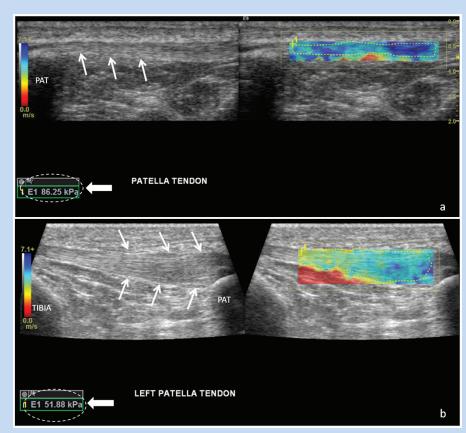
Shear wave elastography (SWE) of the patellar tendon. (a) The grayscale ultrasound image shows a normal patellar tendon (arrows). The corresponding SWE color map demonstrates expected predominantly dark blue signal in the tendon, with corresponding high elasticity measurement indicating a normal tendon. (b) Grayscale image shows abnormal thickening of the patellar tendon (arrows) toward the proximal (patellar) attachment, in keeping with tendinosis. The SWE map demonstrates heterogeneous yellow and light blue signal in the patellar tendon, and the elasticity measurement is decreased compared with that of the normal tendon. PAT, patella.
